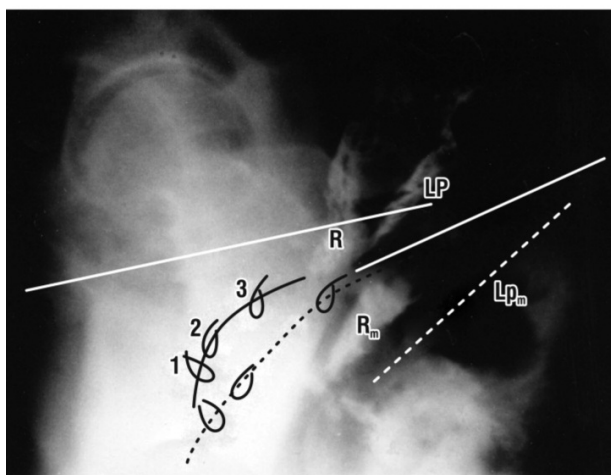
Left side. Micturition x-ray superimposed on resting. Vascular clips have been applied to the midurethra ‘1’. Bladder neck ‘2’ and bladder base ‘3’. Radio-opaque dye has been injected into the levator plate LP, which has been angulated downwards during micturition, as has the rectum ‘R’, which barium paste.
